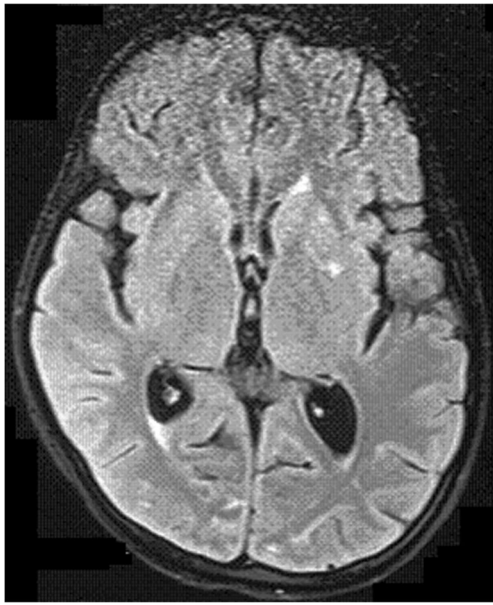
Magnetic resonance imaging FLAIR-weighted axial sections showing small, discrete hyperintense lesion expanding the Virchow-robin space in the left basal ganglia consistent with CNS cryptococcoma
